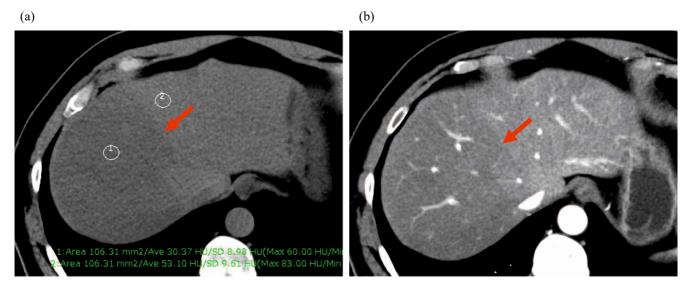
A 46-year-old man with right lobar steatosis. a) Unenhanced CT and b) arterial-phase CT show hepatic steatosis of the right hepatic lobe with straight boundary (arrows). CT attenuation values of the right and the left hepatic lobe on unenhanced CT were 30.4 and 53.1 HU, respectively. Contrast enhancement value of the areas of right lobar steatosis was lower than that of the non-fatty left lobe.
